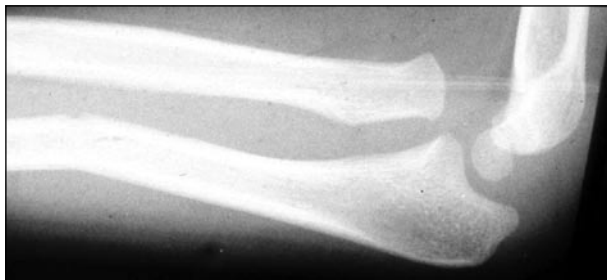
Lateral radiograph of child with chronic Monteggia dislocation and ulnar malunion
